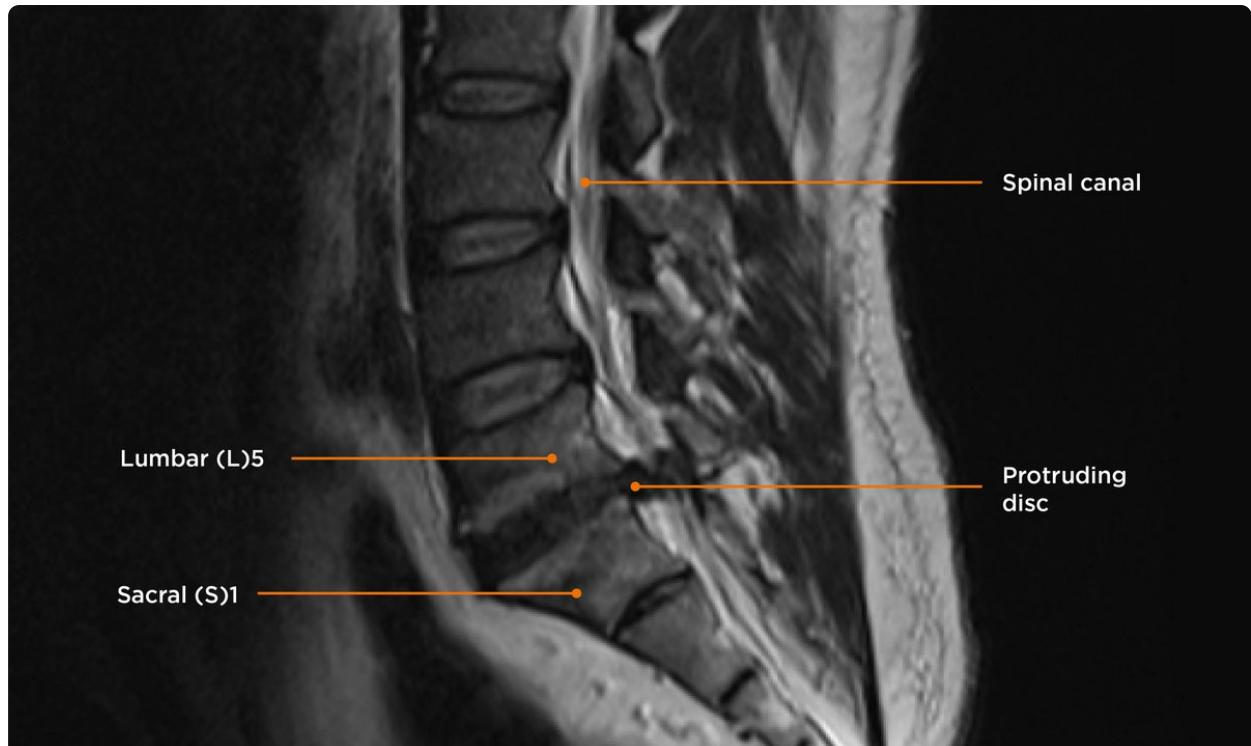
MRI showing a large protruding intervertebral disc pressing on the spinal cord at the lower lumbar area (image courtesy of Radiopaedia.org).
